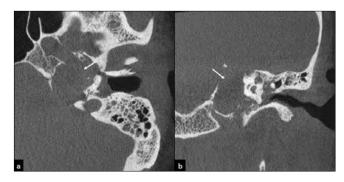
A 38 years-old male with recent vertigo and recurrent otorrhea. Flat-panel CT scans (a: axial; b: coronal) showed a soft-tissue mass occupying the left petrous apex (arrow), determining a large erosion of the anterior, superior and posterior surface of the petrous pyramid, suggesting the presence of an invasive cholesteatoma.
